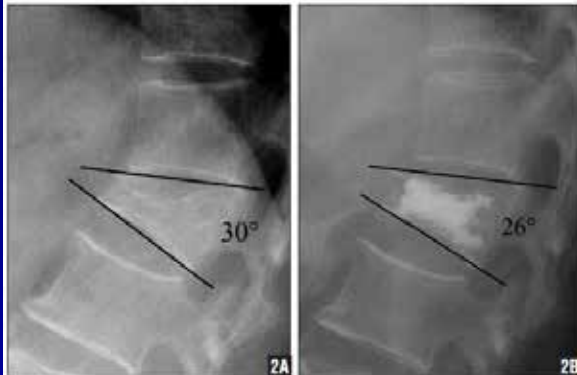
Pre- (A) and postoperative (B) lateral radiographs of a 66-year-old woman with an L1 vertebral compression fracture who was treated with kyphoplasty 3 months after onset of severe back pain showing that the kyphotic angle was corrected from 30° to 26°, respectively. T-score was -2.0 SD.
